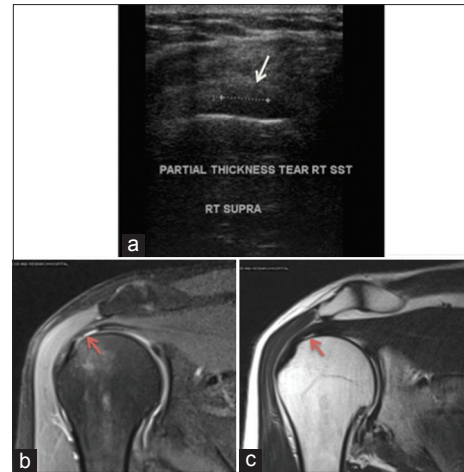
A 57-year-old female patient presented with history of fall on the right shoulder following which she was unable to abduct her arm. On clinical examination, involvement of supraspinatus tendon was suspected. (a) Transverse sonogram demonstrated a hypoechoic defect at the articular surface of the supraspinatus tendon. Overlying bursal surface fibers (white arrow) remained intact; and (b) Coronal oblique PD fat sat. (c) T2W images revealed an articular surface partial-thickness tear involving less than 50% of the tendon thickness (red arrow)
